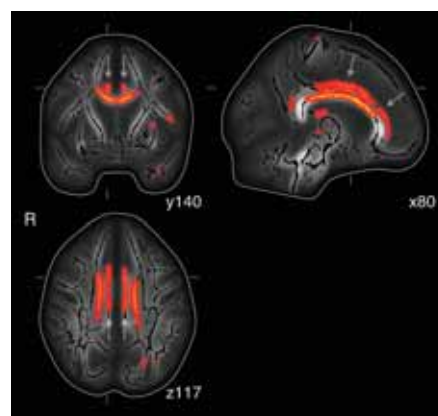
Global white matter atrophy and reduced fractional anisotropy in cingulate bundle. Coronal, sagittal and axial projections of mean fractional anisotropy (FA) MRI image on which the white matter skeleton (black) is projected. MNI coordinates are depicted for each projection. Yellow-to-red colors represent normal-appearing white matter regions with reduced FA in relation to white matter atrophy. Arrows indicate the cingulate bundle on both sides.
